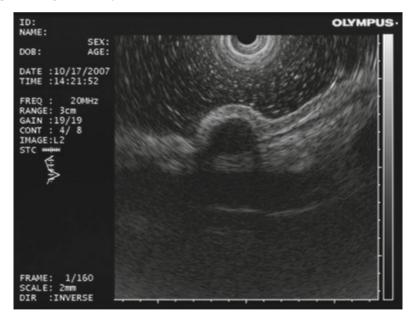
Endosonographic imaging with a high-frequency miniprobe demonstrates a hypoechoic, homogeneous mass arising from the fourth echolayer (muscularis propria). The differential diagnosis includes a small leiomyoma versus gastrointestinal stromal tumor (GIST).
